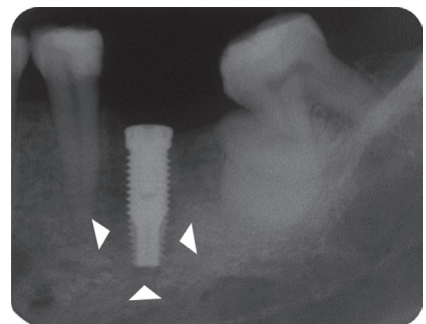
Five weeks after the surgery, the size of IPL had increased on a radiograph with remaining discomfort. Arrow heads depict the extent of IPL.
